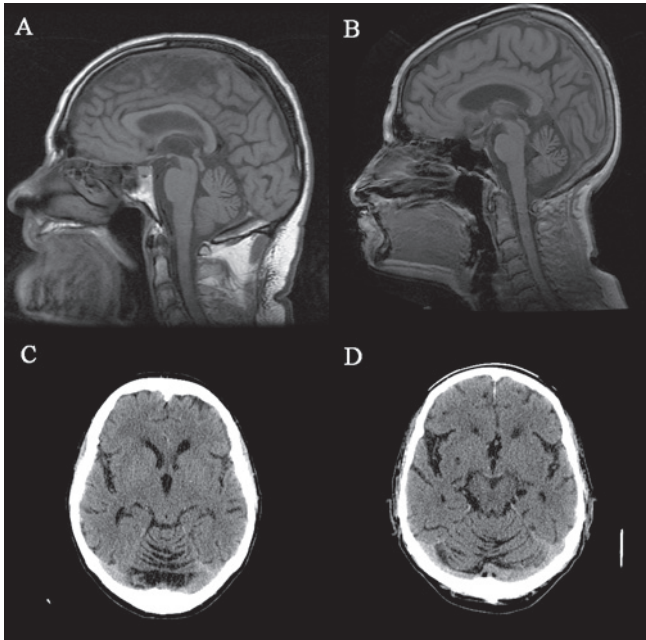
Neuroimaging features of affected individuals. Midsagittal T2 Magnetic Resonance imaging of individual III:13 (A) and individual III:10 (B). Axial Computed Tomography images of individual III:19 (C) and individual III:15 (D).
